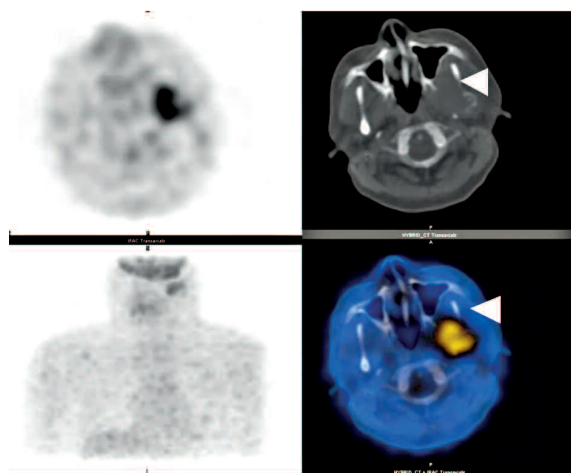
Pre-therapy <sup>18</sup>F-FDG SPET/CT scan showing the parotid and mandibular DTC metastases but no lung metastases.
